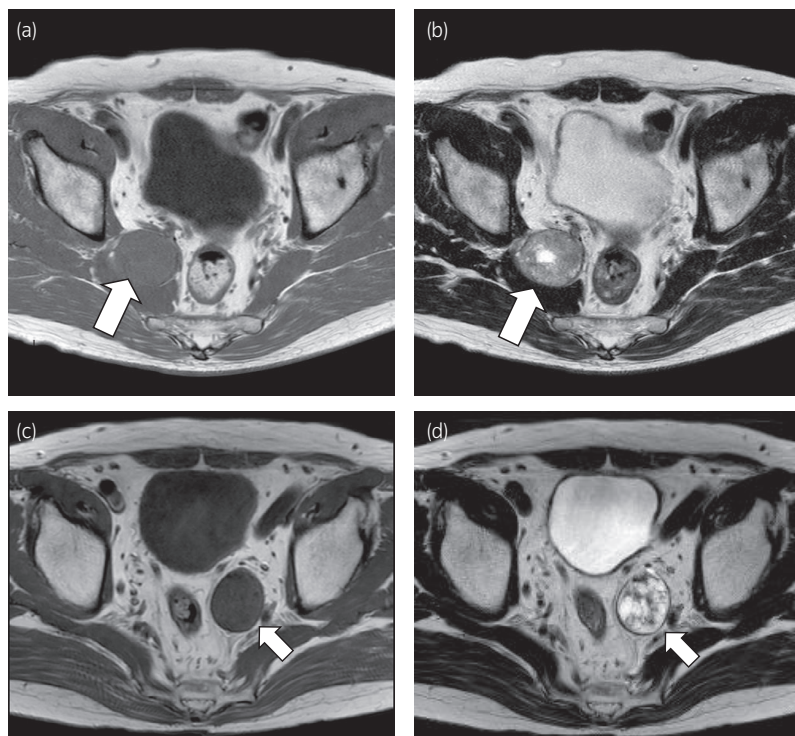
MRI. (a,b) (Patient 1) A tumor lesion measuring 39×33 mm in diameter on the right side of the pelvic floor that was isointense to muscle on T1-weighted images (a). The T2-weighted images (b) showed mild hyperintensity at the margins and hyperintensity on the inside. No contrast enhancement was observed. (c,d) (Patient 2) Pelvic MRI findings revealed a well-circumscribed mass on the ventral side of the left piriformis muscle measuring 38×31 mm in diameter. The inside of the mass was isointense on T1-weighted images (c) and heterogeneously hyperintense on T2-weighted images (d).
